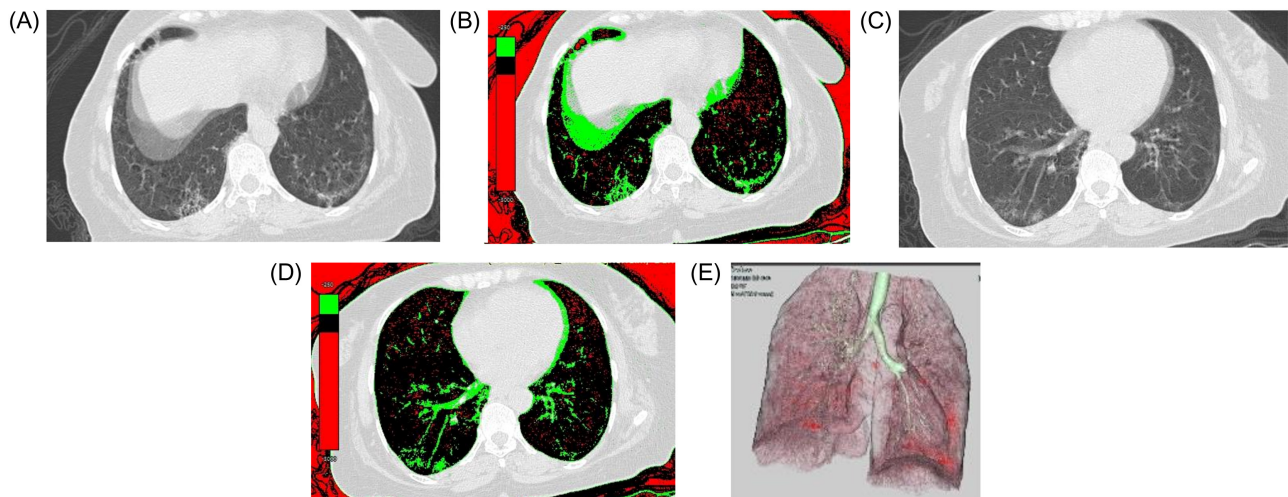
(A and C) Axial CT images showing the volume of HRCT supine in inspiratory phase; in a female patient with normal pulmonary functions test and color overlay maps for lung densitometry. (B and D) Posterior segments of both lower lung lobes showing subpleural reticulation, honeycombing (green colored). CT score was 3, HAA 13 %, and LAA 3.4 %. (E) 3D display of volume of the LAA of both lungs (red colored). CT, computed tomography; LAA, low attenuation areas.
